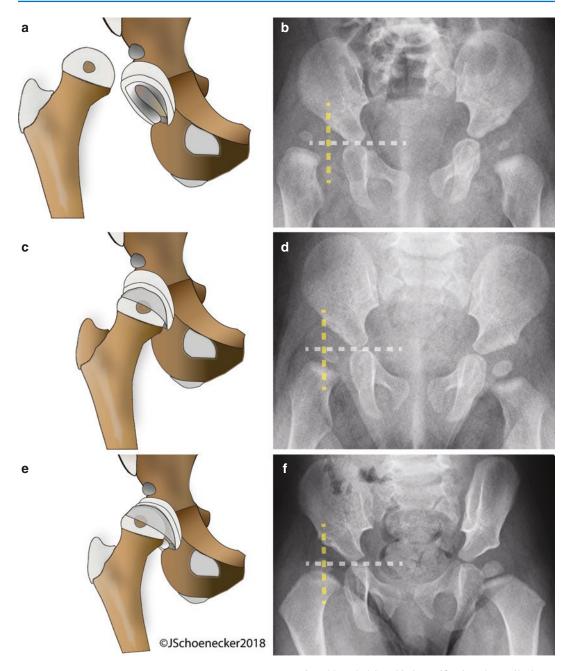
Deformation of the cartilaginous anlage. Problems of shape and/or delay in ossification of the cartilaginous anlage occur early in life. As the cartilaginous anlage is considerably plastic, malformation most commonly occurs from eccentric loading of the proximal femur. In this case an 8-month old female (a) with a dislocated hip observed by (b) radiographs with an ossification center in the superior lateral quadrant defined by Hilgenreiner's line (white dashed line) and Perkin's line (yellow dashed line). (c) The patient undergoes successful closed reduction with (d) restoration of the ossification center to the inferior medial quadrant of Hilgenreiner's and Perkin's line. At this
